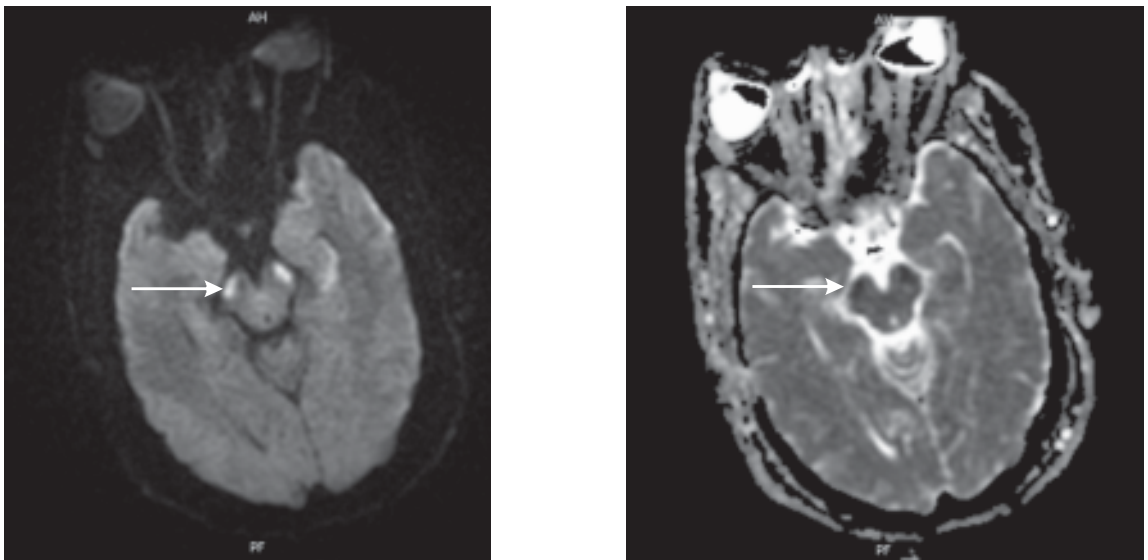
Diffusion weighted MRI (DWI) (top figure) showed increased signal in the corticospinal tracts in the internal capsule and cerebral peduncles bilaterally (arrow). Apparent diffusion coefficient maps (ADC) (bottom figure) showed a corresponding decreased signal (arrow).
